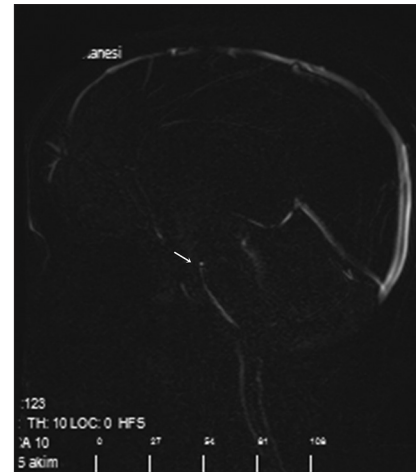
Sagittal cine phase-contrast magnetic resonance imaging after 6 years. Continuous (patent) cerebrospinal fluid flow from the foramen of Monro to the prepontine cistern (white arrow) and aqueductal flow are observed
